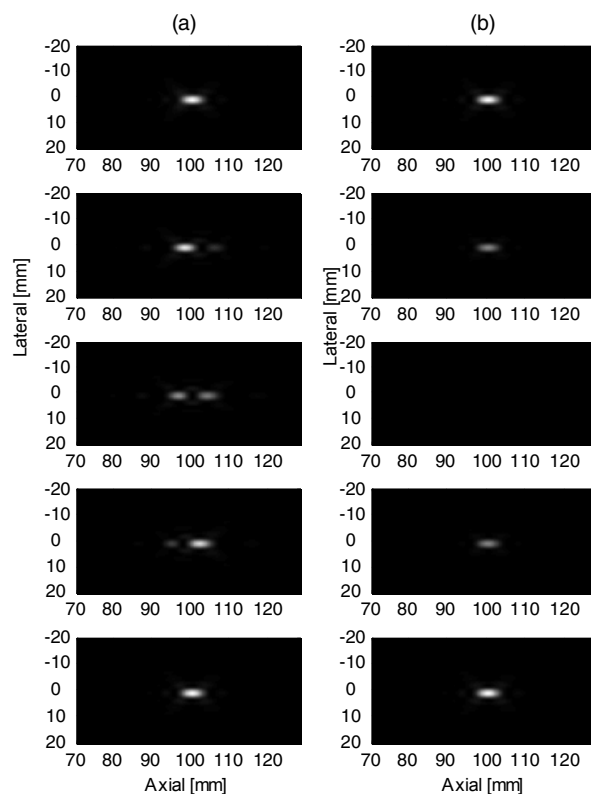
The acoustic radiation force field at 4 ms intervals (from top to bottom) produced by (a) two overlapping focused ultrasound beams at two different frequencies $\Delta f = 50$ Hz and (b) one-beam modulated at 50 Hz. Note the spatial invariance of the radiation force field using the one-beam configuration versus the alternative.
